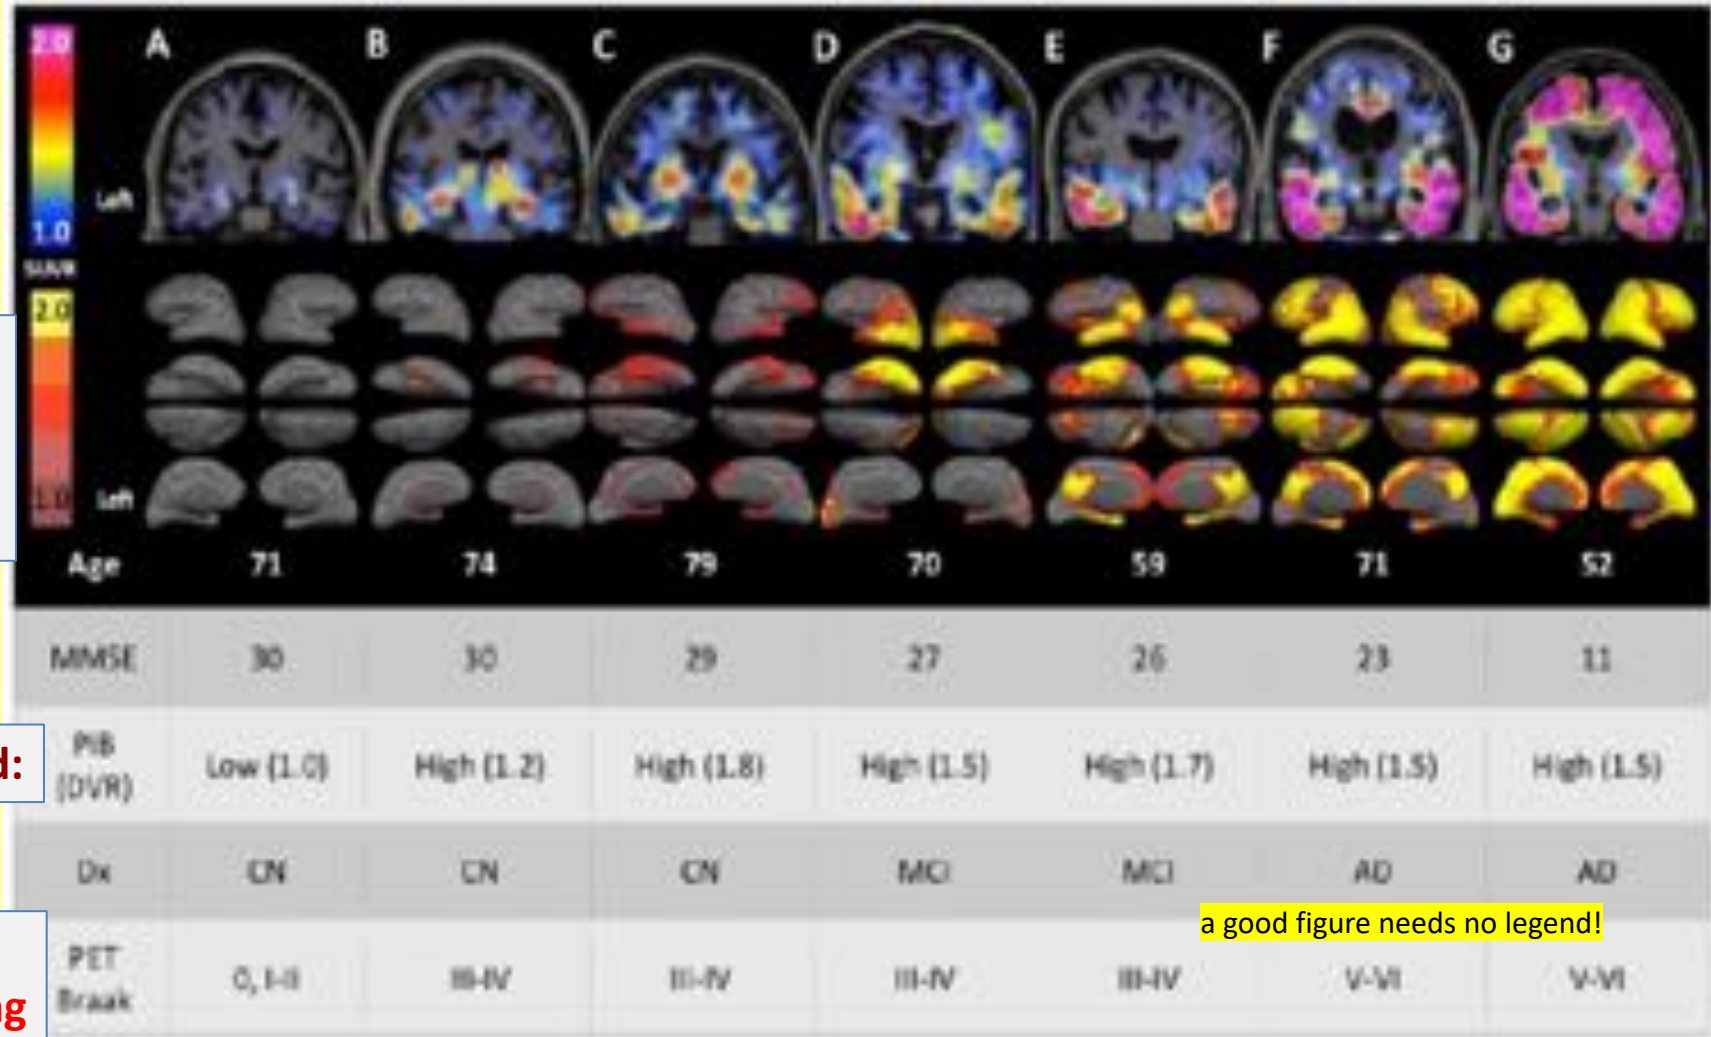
Cortical patterns of ^{18}F T807 binding. Coronal ^{18}F T807 positron emission tomographic (PET) images (top row) and whole-brain surface renderings of standardized uptake value ratio (SUVR; cerebellar reference; second row) from 3 clinically normal (CN) and 4 impaired (2 mild cognitive impairment [MCI] and 2 mild Alzheimer dementia [AD] dementia) participants. Top: (A) A 71-year-old CN subject with low amyloid β (A β) by Pittsburgh compound B (PiB) PET (mean cortical distribution volume ratio [DVR] = 1.0) had low, nonspecific ^{18}F T807 binding in cortex, consistent with a Braak stage less than II/IV. (B) A 74-year-old CN subject with high A β (DVR = 1.2) with ^{18}F T807 binding in inferior temporal cortex, left>right, consistent with Braak stage III/IV. (C) A 79-year-old CN subject with high A β (DVR = 1.8) had binding in inferior temporal neocortex, consistent with Braak stage of III/IV. B and C show focally intense subcortical uptake that is likely due to off-target binding (see Discussion). (D-G) Cognitively impaired participants all with high A β and with successively greater levels of cortical ^{18}F T807 binding successively involving temporal, parietal, frontal, and occipital cortices. Bottom: ^{18}F T807 SUVR calculated at vertices (see Subjects and Methods) indicating the extent of cortical binding, with left hemisphere views (lateral, inferior, superior, medial) at left. The 52-year-old AD dementia patient (G) showed confluent ^{18}F T807 binding that is nearly pancortical, sparing only portions of primary cortex and consistent with Braak stage V/VI. Ds = diagnosis; MMSE = Mini-Mental State Examination; PET Braak = estimate of Braak stage based on the anatomic pattern of T807 binding assessed visually and quantitatively in regions
